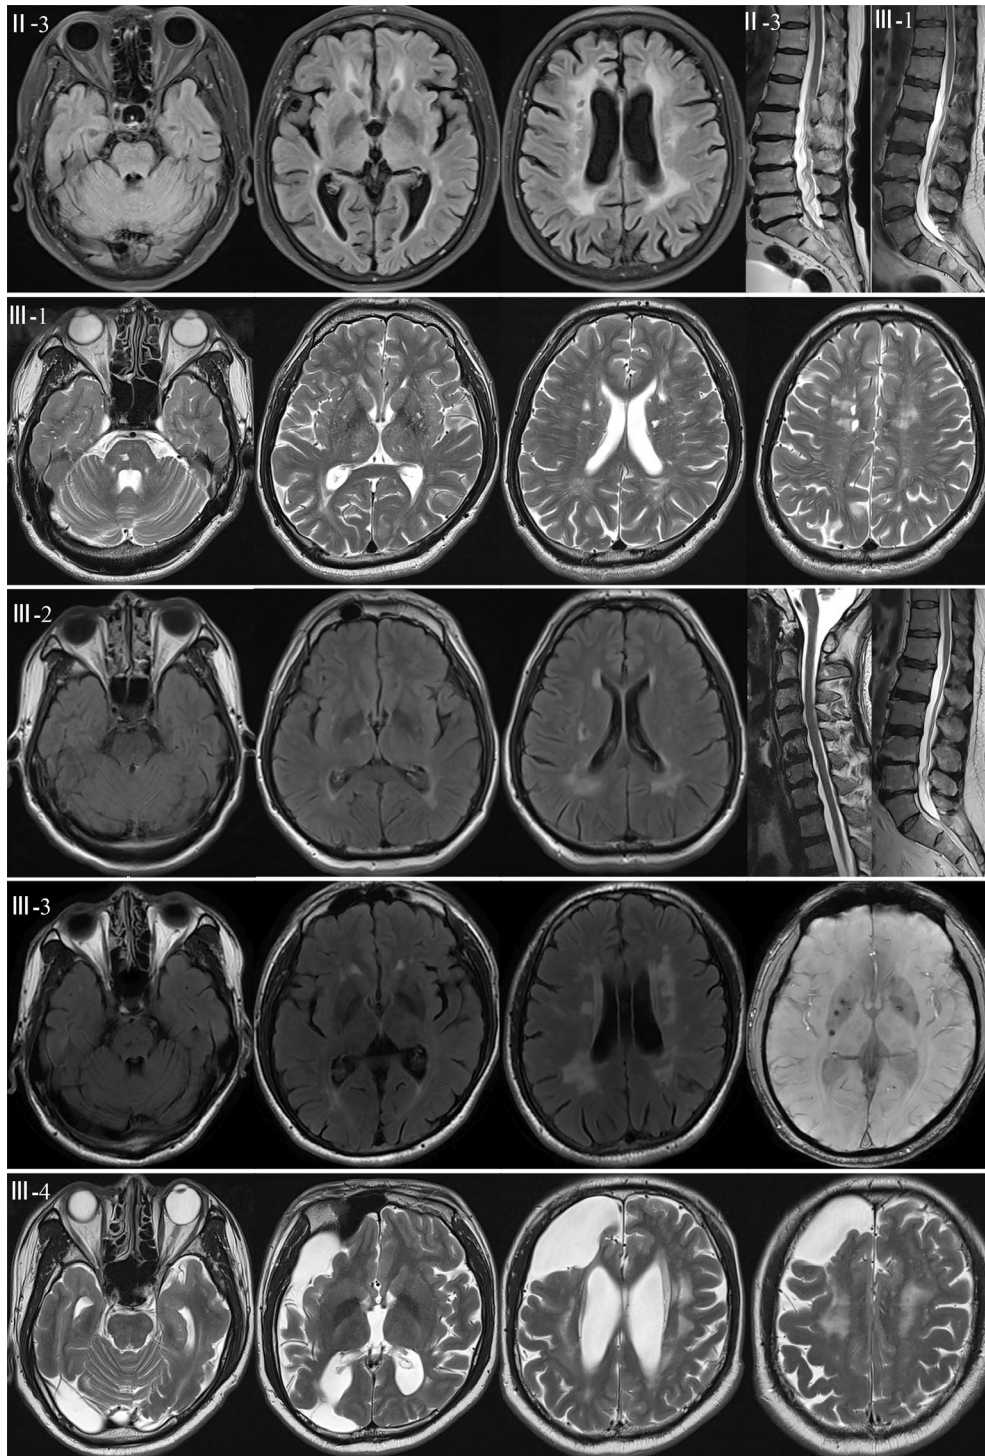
MRI findings in patients with heterozygous *HTRA1* mutation. MRI from family 8 with heterozygous *HTRA1* mutation. Fluid-attenuated inversion recovery images of the brain show symmetrical hyperintensities in the periventricular area, whereas anterior temporal poles were not obviously involved (II-3, III-2, and III-3); lacunar infarcts in the deep brain white matter and basal ganglia (II-3, III-2, and III-3); T2-weighted images of the brain revealing visible perivascular spaces in the basal ganglia and deep brain white matter (III-1). Susceptibility-weighted images demonstrate microbleeds in the basal ganglia (III-3); the arachnoid cyst is noted in the right temporal and frontal lobe of III-4; T2-weighted cervical and lumbar MRI revealed multilevel degenerative disease, including disc herniation, canal stenosis, and degeneration of vertebral bodies (II-3, III-1, and III-2).
